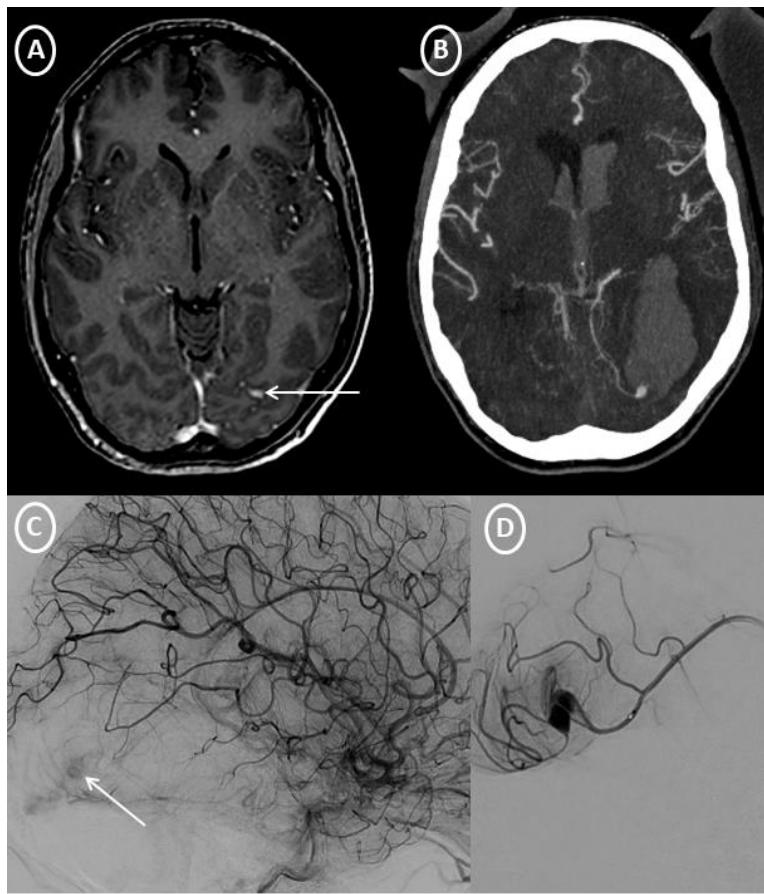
A 23 yo male, IE was diagnosed without abnormality detected on the first CT-scan realised one day after admission. a MRI CE-3DT1-EG sequence 10 days after admission for persistent headache, showed left occipital sulcal enhancement. b CT-scan 14 days after admission, reveals parenchymal and ventricular hemorrhage associated with saccular occipital IIA. c, d DSA showed saccular IIA of a distal occipital branch of the left postérior cerebral artery.
